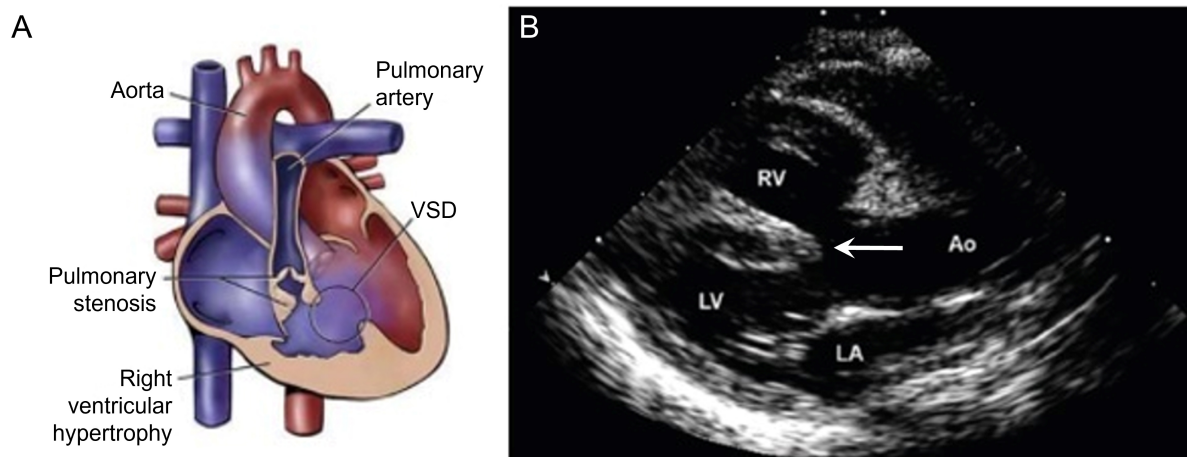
Tetralogy of Fallot. (Modified from Vyas HV, Johnson JA, and Eidem BW. Tetralogy of Fallot. In [13]; used with permission of Mayo Foundation for Medical Education and Research.) (A) The 4 anatomic components of tetralogy of Fallot: VSD, right ventricular outflow tract obstruction, overriding aorta, and right ventricular hypertrophy. (B) Parasternal long-axis echocardiographic view showing the VSD (arrow) and overriding aorta. Ao, aorta; LA, left atrium; LV, left ventricle; RV, right ventricle; VSD, ventricular septal defect.
